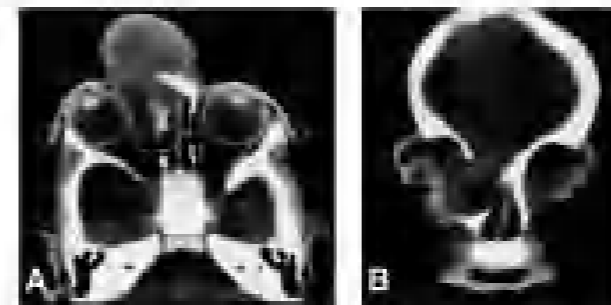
Preoperative axial (A) and coronal (B) CT scans show uniform defect with partially neural tissue herniation.
